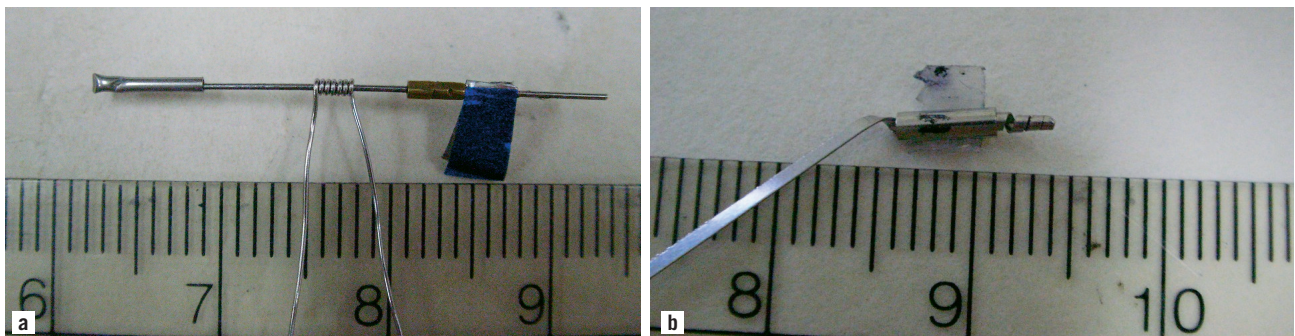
a. Ultrasound micromotor with an external stator. A flexural wave propagates along the coiled acoustic waveguide. This wave crawls like a caterpillar over the rotor, and makes it rotate. b. Ultrasound micromotor with an internal stator. (Scale is in cm)
